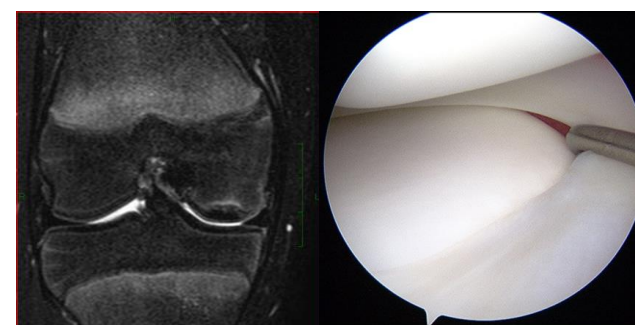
13yo Girl, MFC inferior-central type, stable lesion. On MRI, high signal rim can be seen at the inferior-central part of MFC. Arthroscopically medial meniscus is easily sifted medially by probing.
